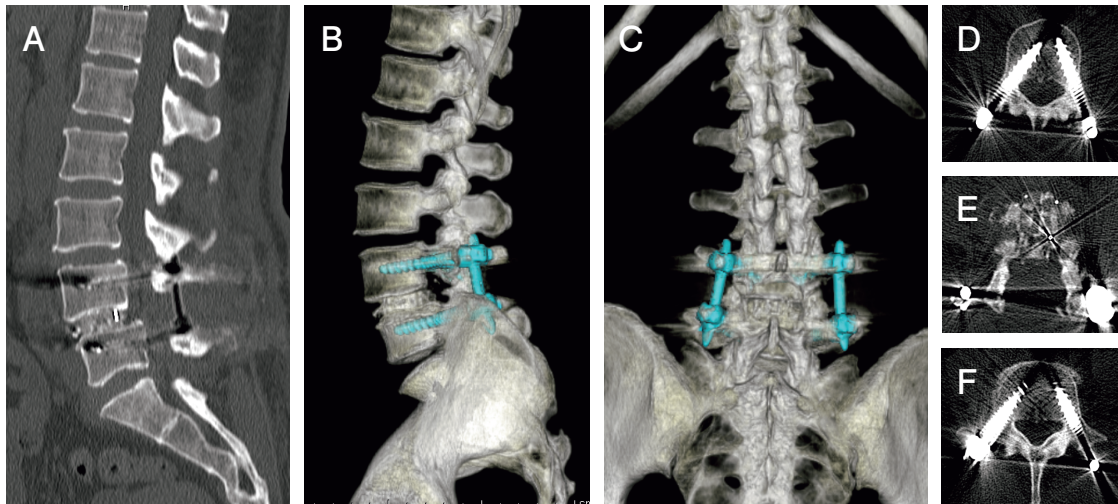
Postoperative CT. The sagittal reconstruction image shows a solid bony fusion. A, Sagittal reconstruction image; B, 3-D lateral image; C, 3-D posterior image; D, L4 level; E, L4/5 level; F, L5 level.
